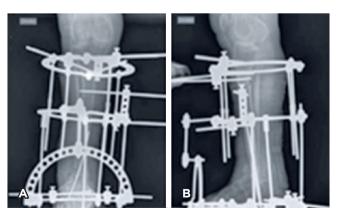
Anteroposterior (A) and profile (B) radiographs of the right lower limb after the first single-time approach of attempting talar tibial arthrodesis, fixed with Kirschner wire and assembly of a circular external fixator encompassing the tibial block and foot.
